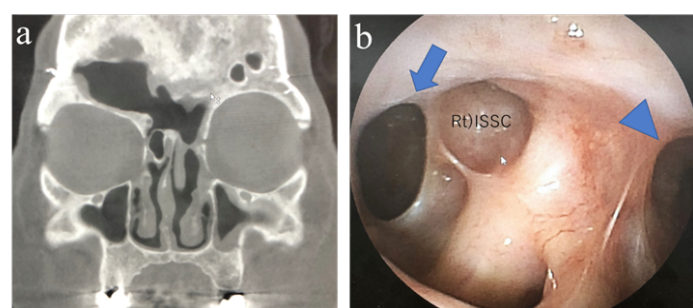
Findings at 1 year after surgery. a, CT coronal section of the paranasal sinuses shows a wide opening between the right frontal sinus mucocoele and the nose. b, Nasal endoscopic findings also show a wide opening between the right frontal sinus mucocoele and the nose (arrow). Open area of the left frontal sinus (arrowhead).
